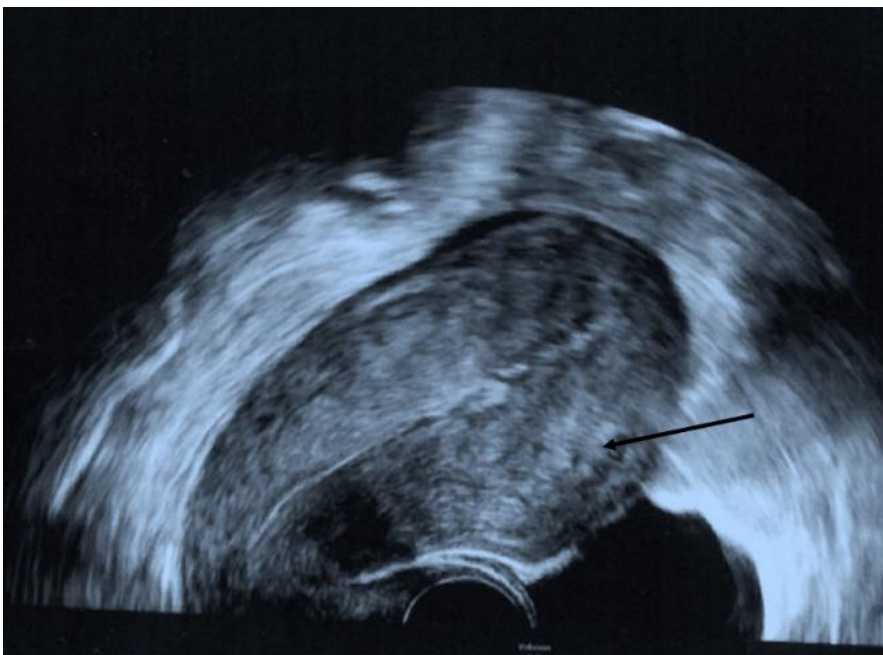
Transvaginal ultrasound revealed a thin endometrial echo at 4 mm with a fibroid in the anterior uterine wall measuring 4 x 4.5 cm (arrow)
